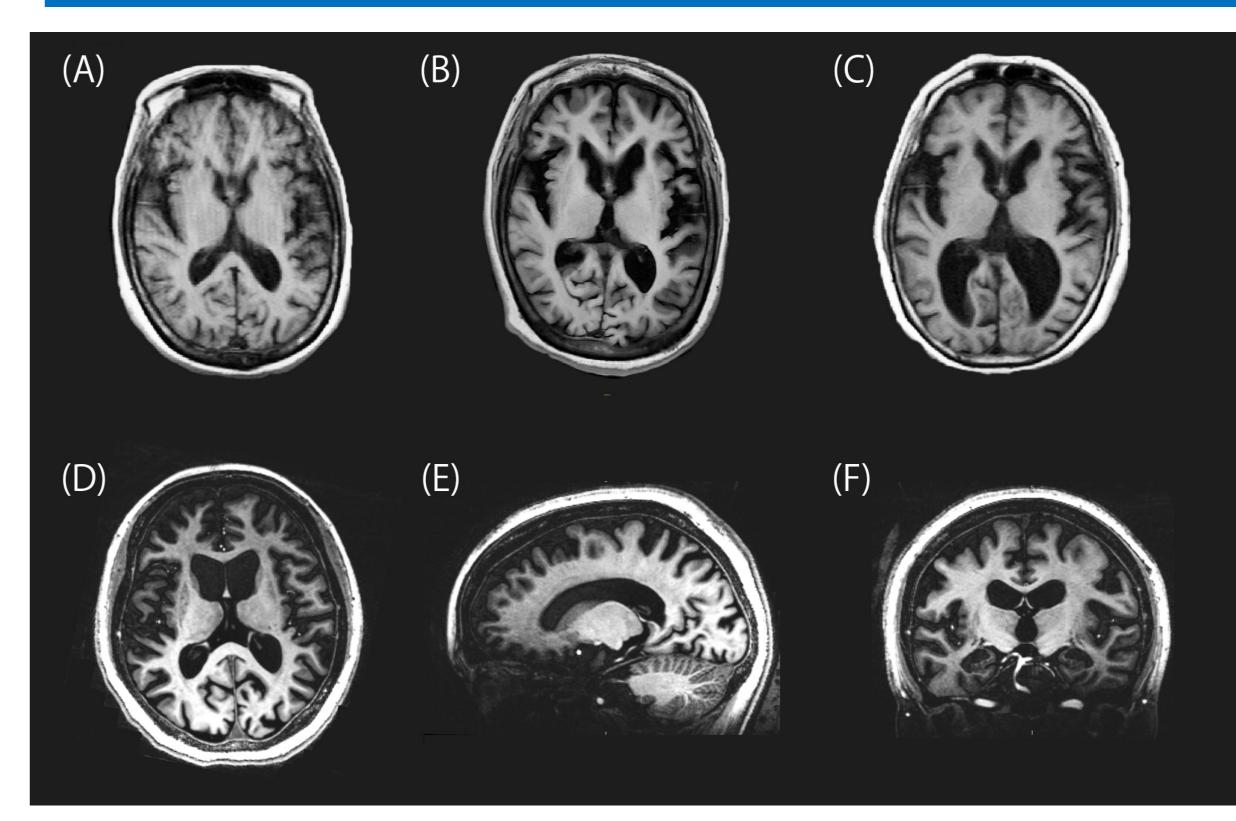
T1-weighted magnetic resonance imaging (MRI) images of typical HD patients with psychosis.
